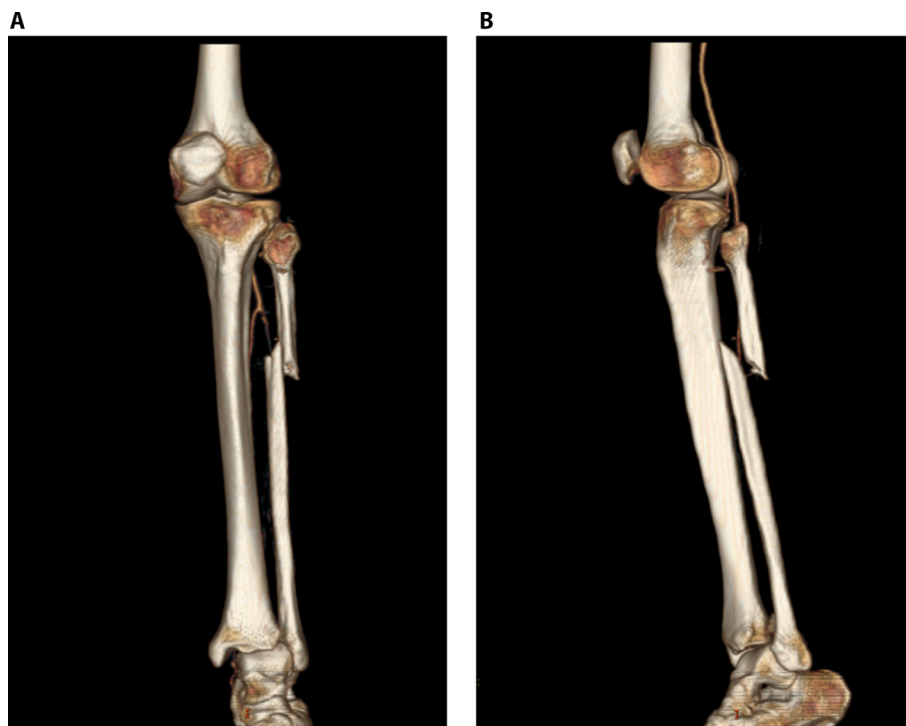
Pre-surgery CT 3D Rendering, A: Antero-posterior view, B: Lateral view.
